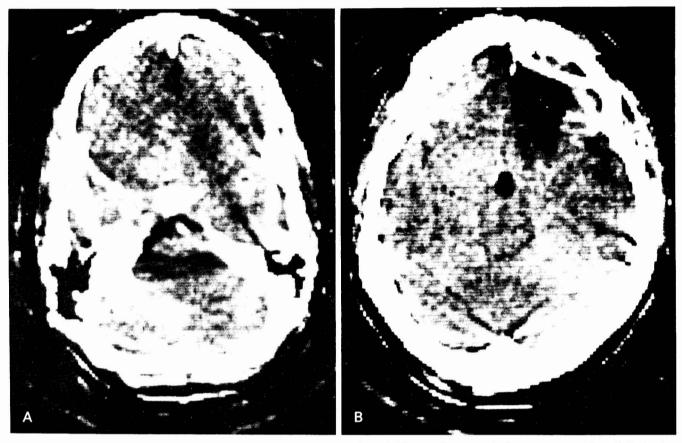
Case 6. A, enhanced CT scan after two previous operations; B, enhanced CT scan after removal of recurrent tumor through the lamina terminalis at a third operation.
